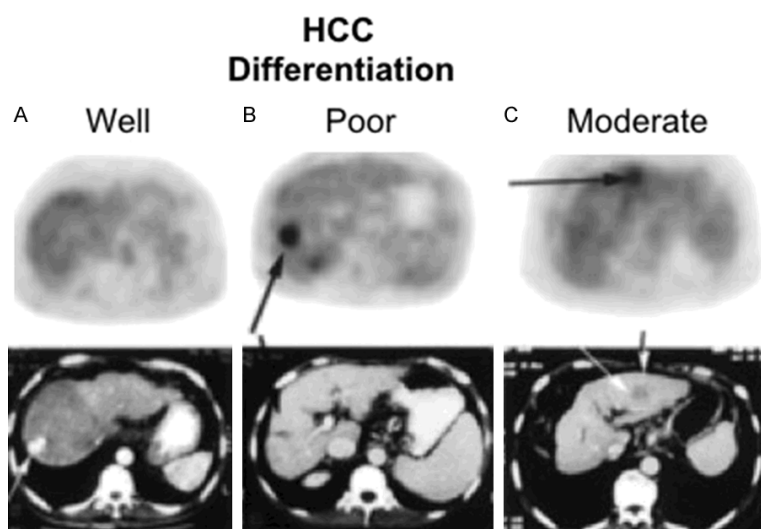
FDG PET/CT images of patients with HCC (selected transaxial PET and CT). Well-differentiated HCC with no increased FDG uptake (A). Poorly differentiated HCC with focally increased FDG uptake (B). Moderately differentiated HCC with mild to moderately increased FDG uptake (C). Reprinted with permission from Society of Nuclear Medicine and Molecular Imaging (46).
